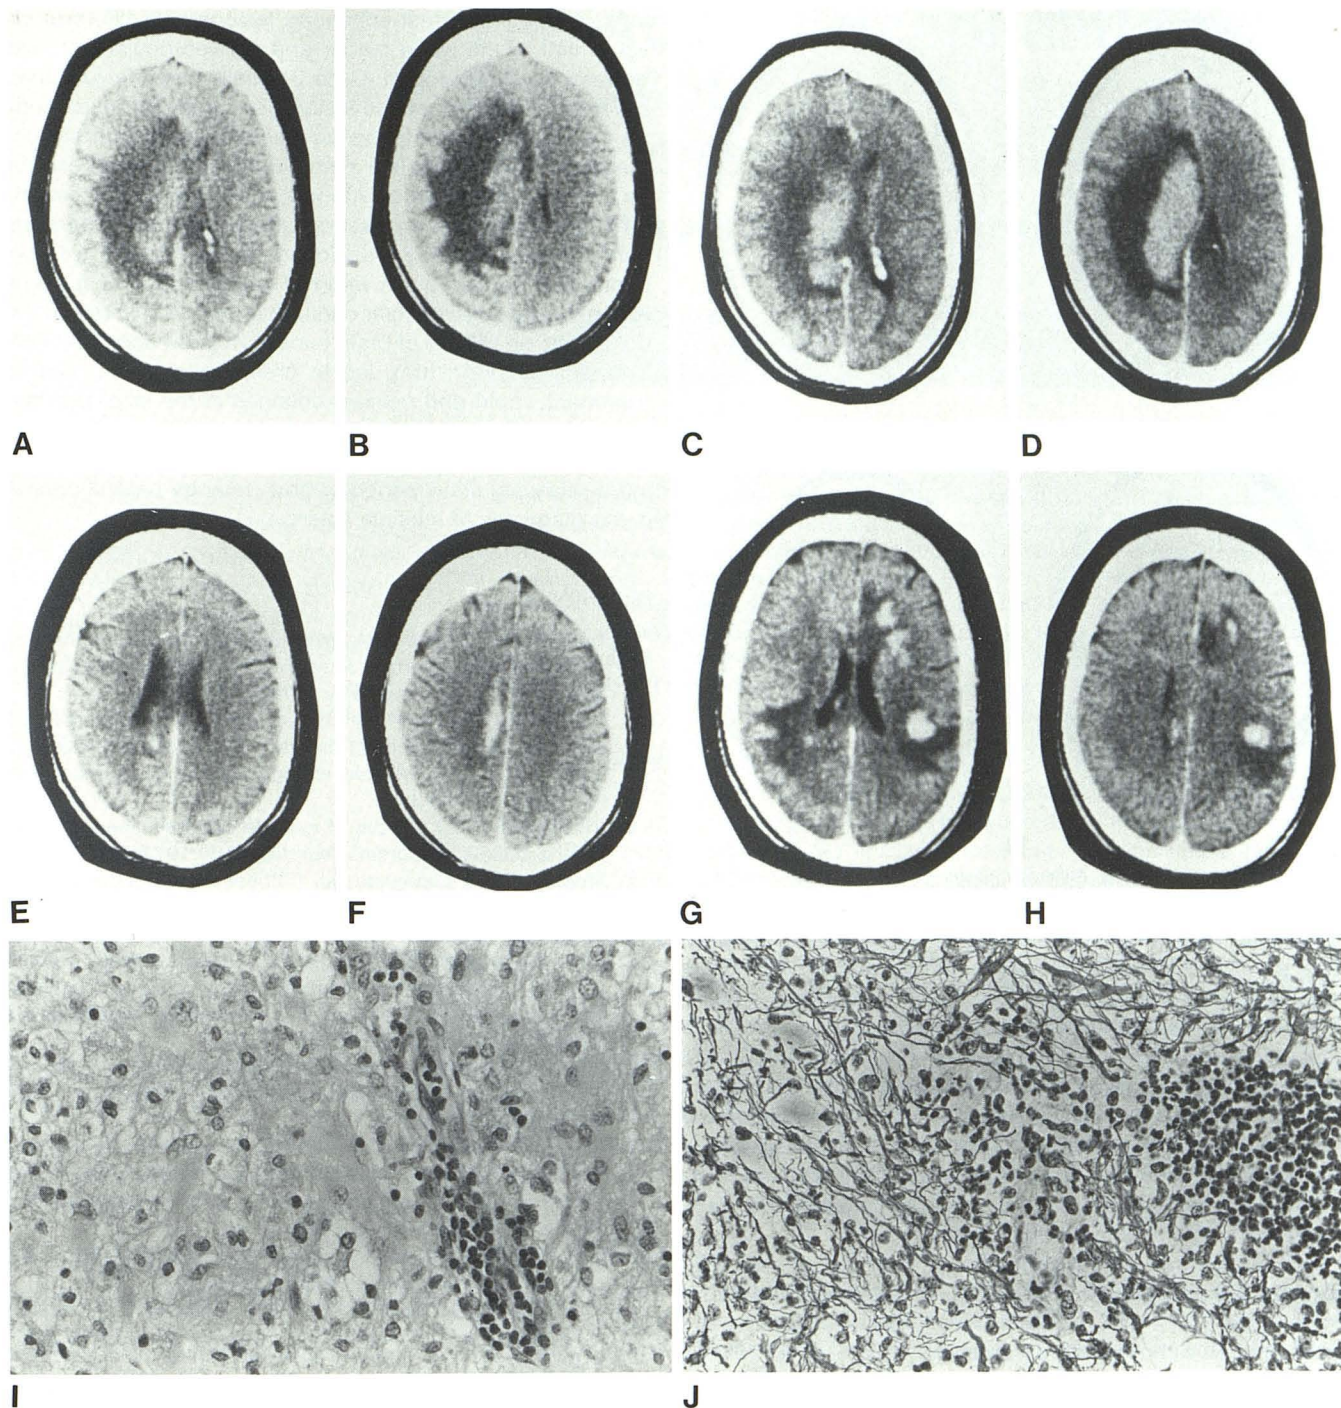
Case 2. Initial CT scans without (A and B) and with (C and D) contrast enhancement. Enhancing mass in white matter of right frontoparietal region is  $8 \times 3$  cm. Prominent zone of edema borders mass. E and F, 3 weeks later with contrast enhancement. Mass in white matter of right frontoparietal region has diminished greatly, contemporary with steroid treatment. G and H, 6 weeks later. Contrast enhancement shows several lesions, decrease in density of white matter, and slight periventricular enhancement.
